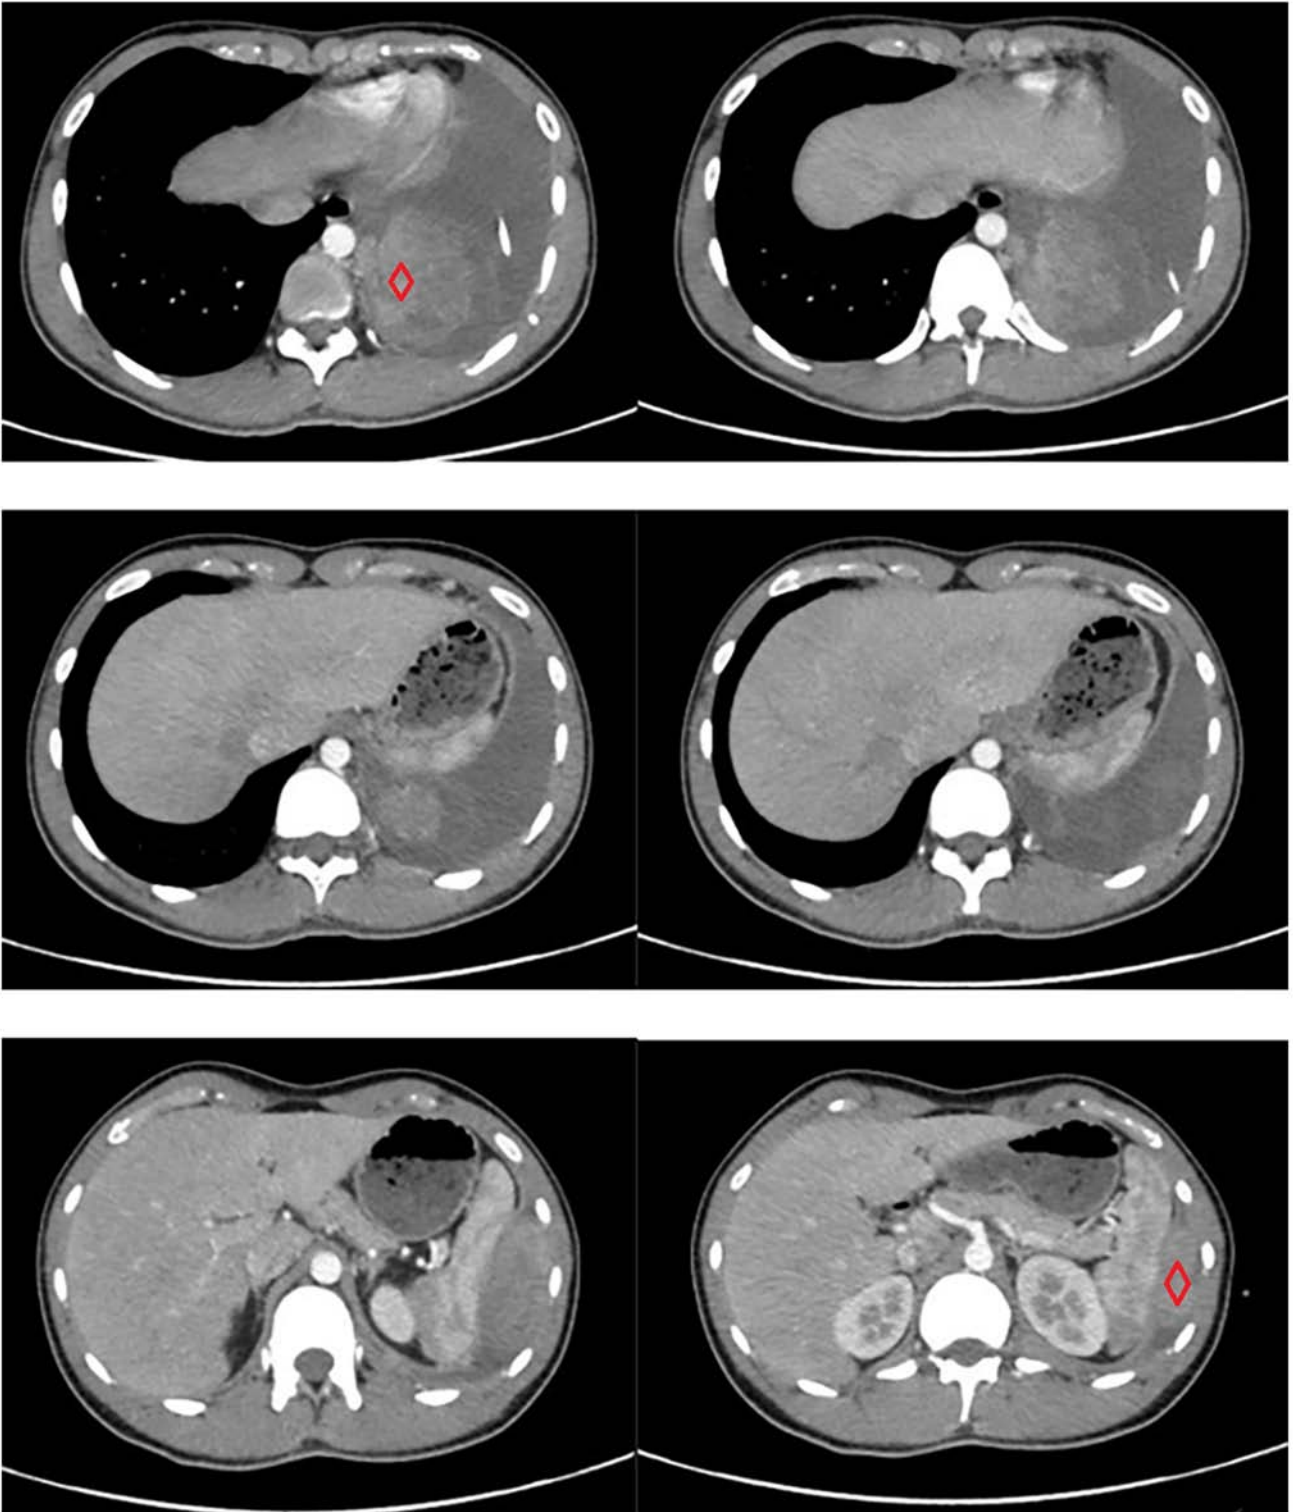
Computed tomography of the chest showed two tumors in the left parietal pleura (7.8x2.8 cm; 6.5x5.8 cm; red squares).
